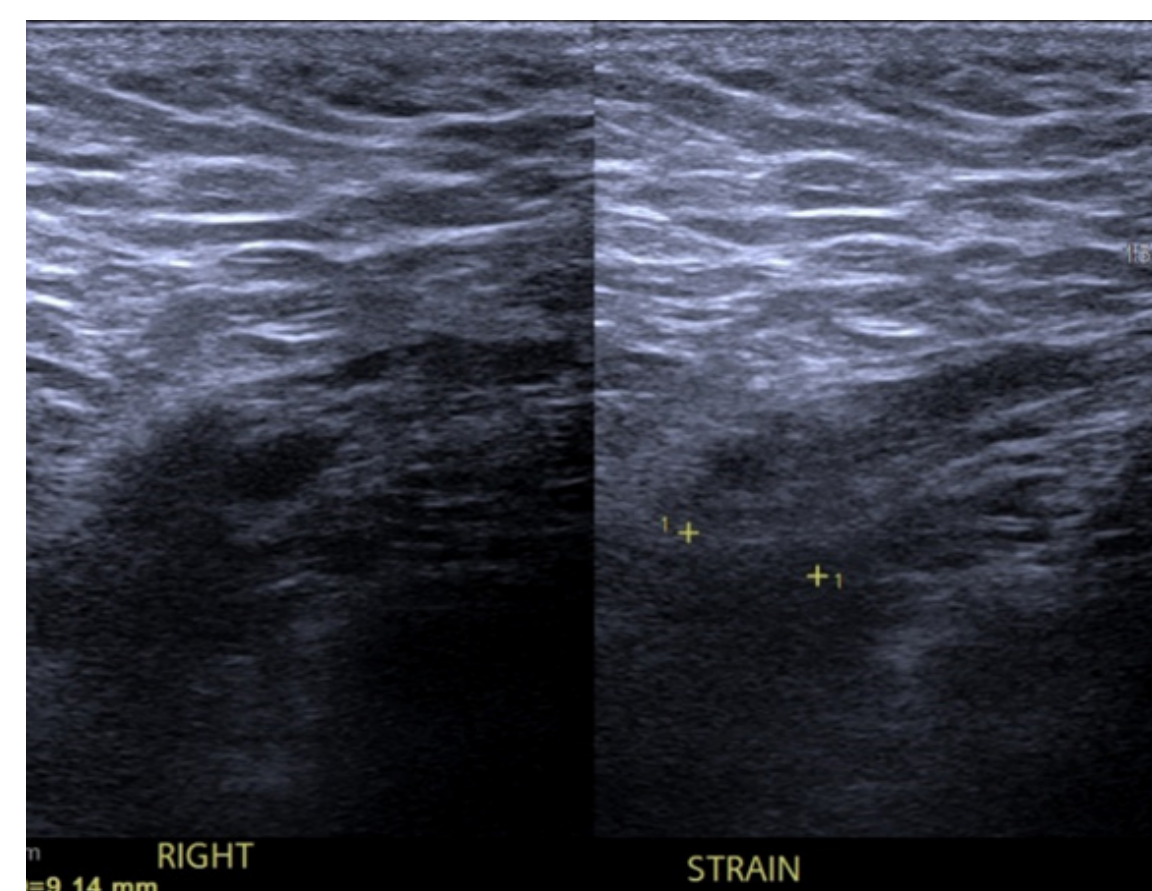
Ultrasound right inguinal hernia Patient A
